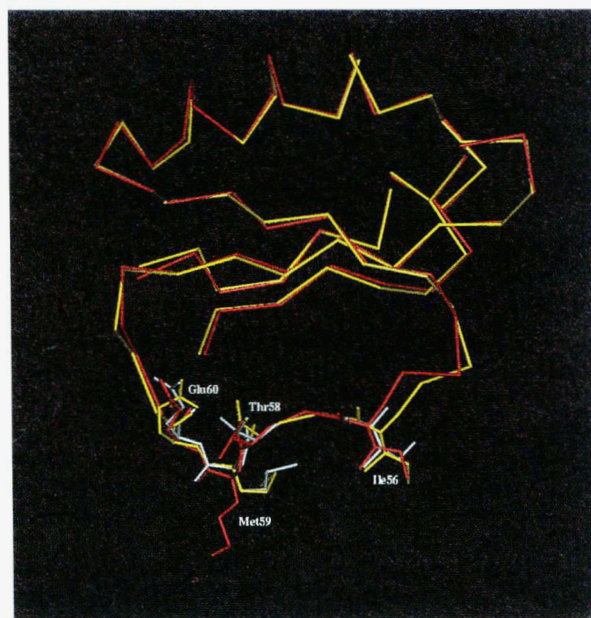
Results of side-chain conformational search for residues Ile 56, Thr 58, Met 59, and Glu 60 of chymotrypsin inhibitor complexed with subtilisin. Only C α traces and residues Ile 56, Thr 58, Met 59, Glu 60 are shown. The structures are color-coded as follows: red, lowest binding free energy structure without side-chain search; white, lowest binding free energy structure with side-chain search; yellow, inhibitor in the X-ray structure of the complex.
